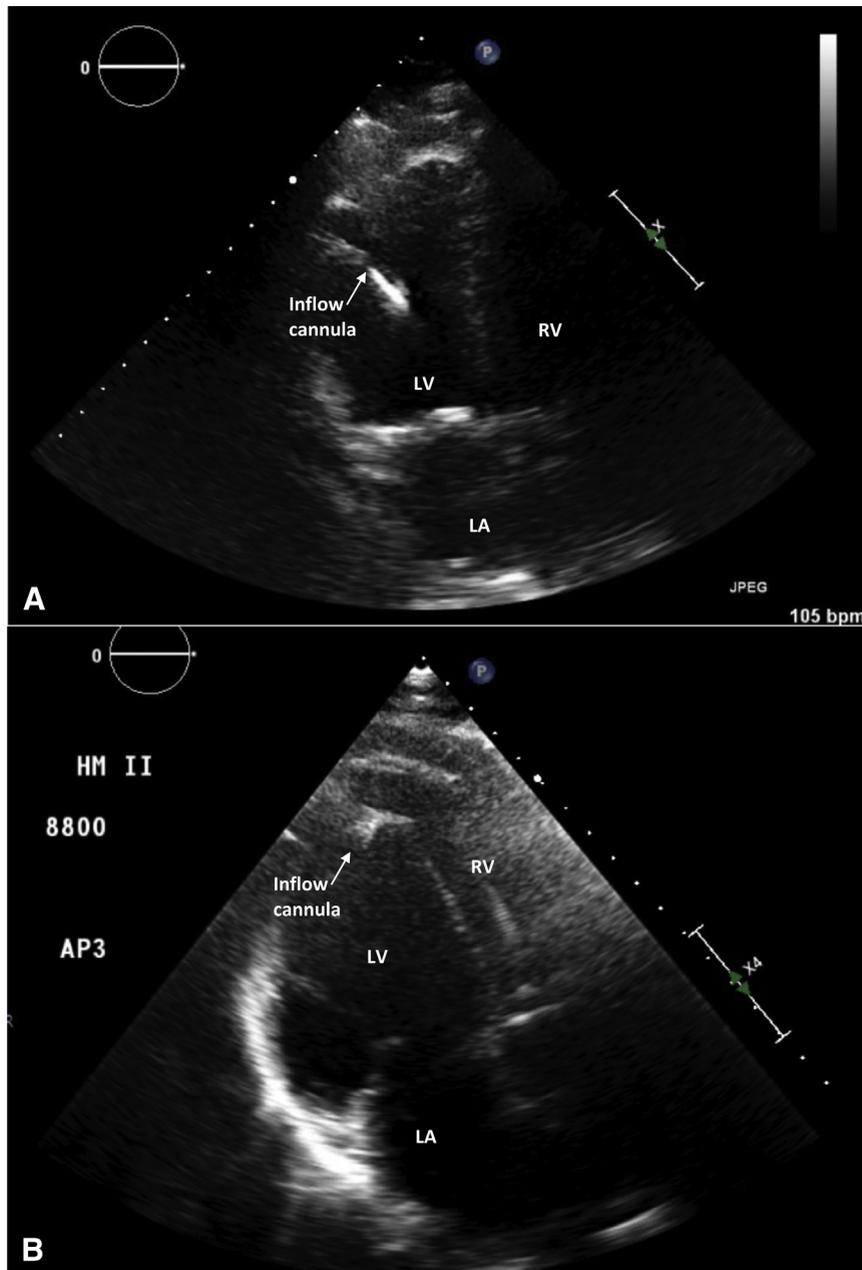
Transthoracic echocardiogram of the case patient post left ventricular assist device placement showing appropriate placement of inflow cannula (A) compared with immediately post ventricular tachycardia event with orientation of cannula toward the intraventricular septum (B). RV = right ventricle; LV = left ventricle; LA = left atrium.
